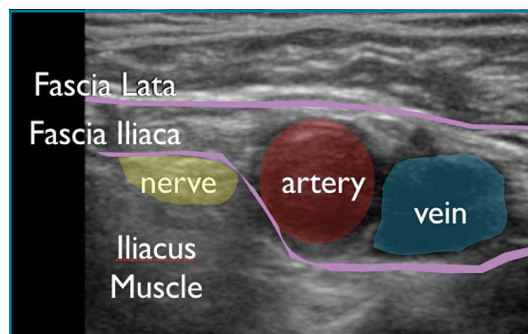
Ultrasound image of the femoral nerve, identified by its flat, hyperechoic, honeycomb appearance in short axis overlying the iliacus muscle adjacent to the femoral artery.
